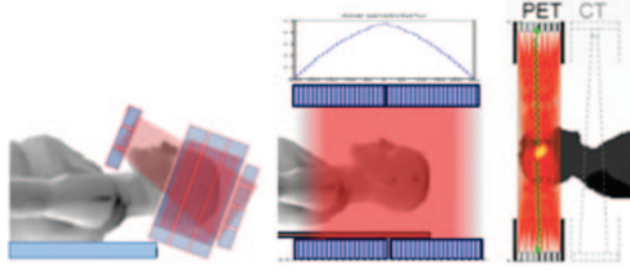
Two major geometries as options for a dedicated brain PET imager. On the right we show the standard brain imaging geometry of the clinical PET/CT scanner. On the left we show an example of a tight compact (but not wearable) helmet design. The TopHat compact helmet-style robust imager shown here, unlike other helmet designs, avoids curved surfaces at the top and bottom. Two detector panels, above and below the head, are added to the central multi-ring cylinder section. The mini-Explorer type approach is shown in the middle. This cylindrical design may have about 50 cm axial length, with improved 3D spatial resolution (smaller scintillator pixelation and good DOI), and with improved TOF timing compared to the total-body Explorer design.
